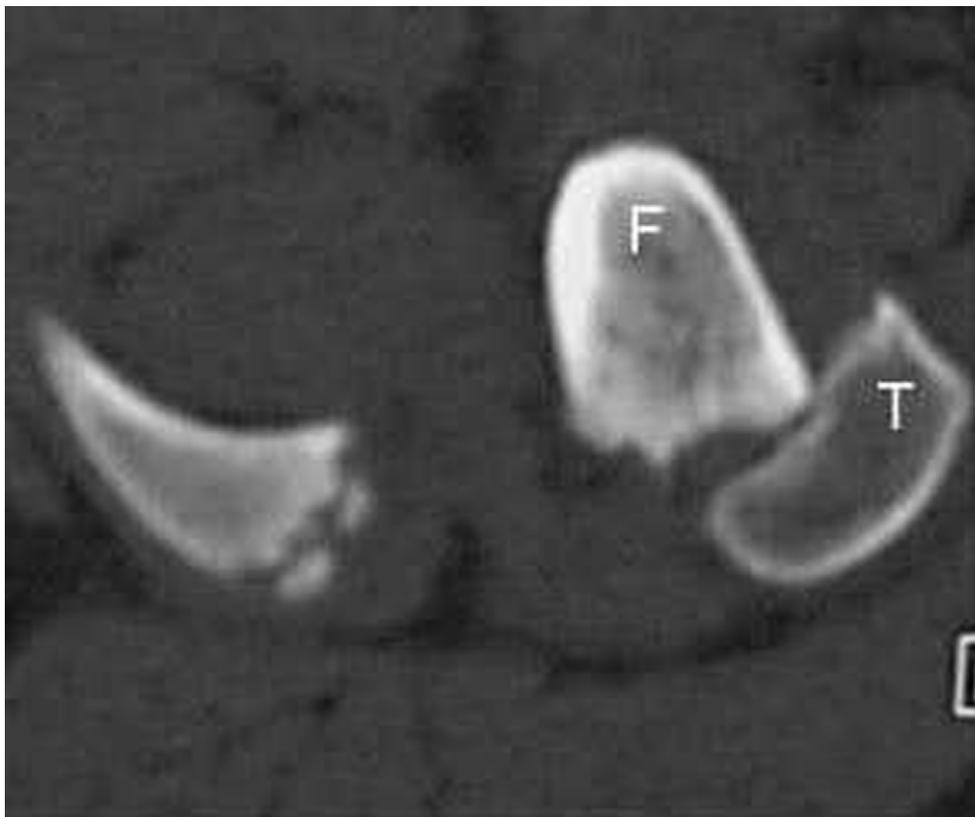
CT image showing avulsion of the left greater trochanter. The trochanteric apophyseal fragment (T) is lying in a neutral position anterior to the externally rotated femur (F).
